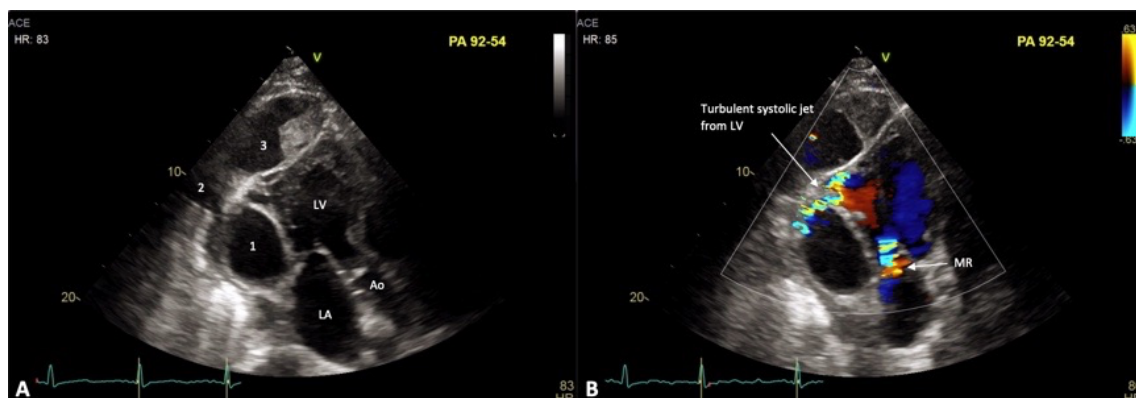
A. 2D transthoracic echocardiography, apical 3-chamber view. LV=left ventricle; LA=left atrium; Ao=aorta; Numbers to 3 are the multiple locations of the giant pseudoaneurysm. B. Color-Doppler echocardiography at apical 3-chamber view.
